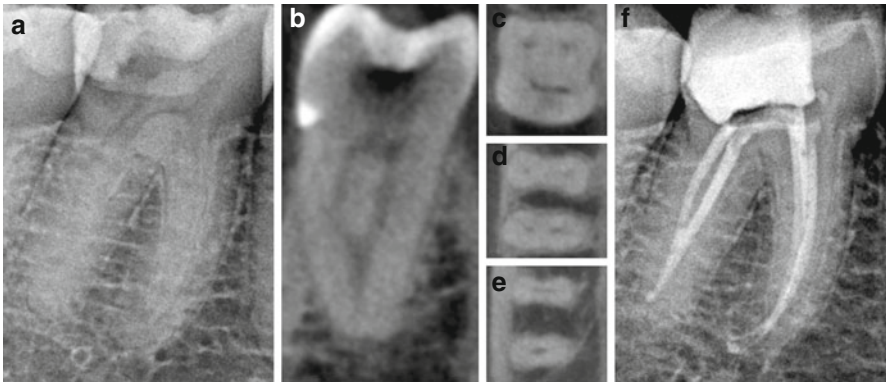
Preoperative periapical radiograph of a right mandibular first molar (a) with corresponding coronal CBCT slice of the distal root (b) demonstrating canal confluence of the root canal system in the apical third. The axial CBCT slices captured from the coronal third (c), mid-root (d), and apical third (e) demonstrate canal confluence in the apical third of the root canal system in both the mesial and distal roots. Post-endodontic periapical radiograph demonstrates proper management of all identified root canal systems (f)
